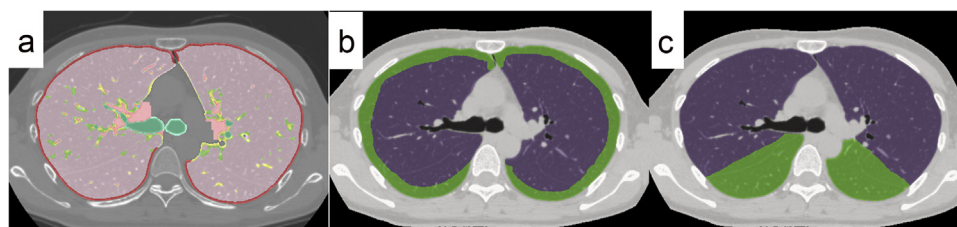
Distribution pattern of the lesions and subpleural area on computed tomography (CT) images.
